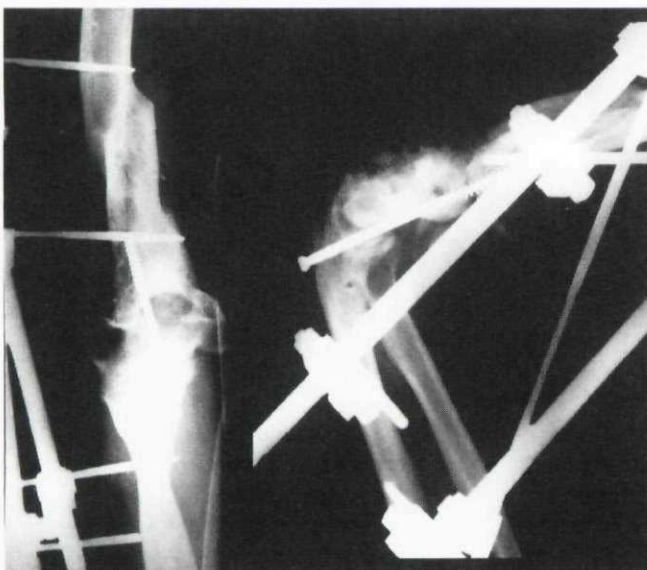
X-rays obtained immediately after elbow arthrodesis, with combined external and internal fixation (left, anteroposterior projection; right, left lateral projection).
